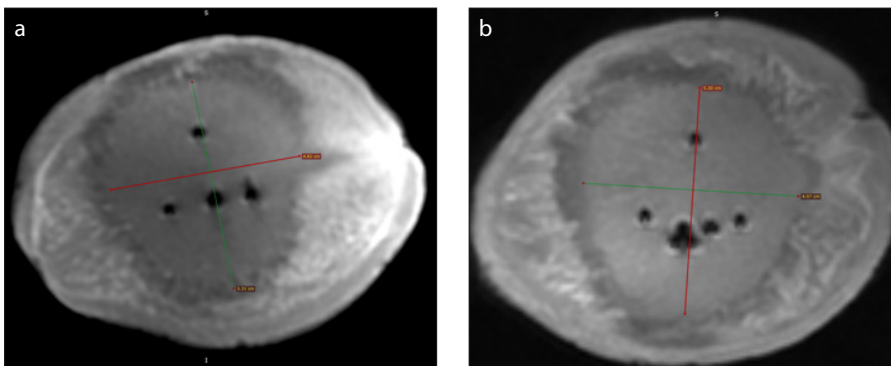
a, b. Magnetic resonance images of the ablated tubers in the three-probe experiment, showing arcing of the ablation margins towards the side of the surgical clips when placed eccentrically. Surgical clip positioned at the edge (a) and outside (b) of the ablation margins.
